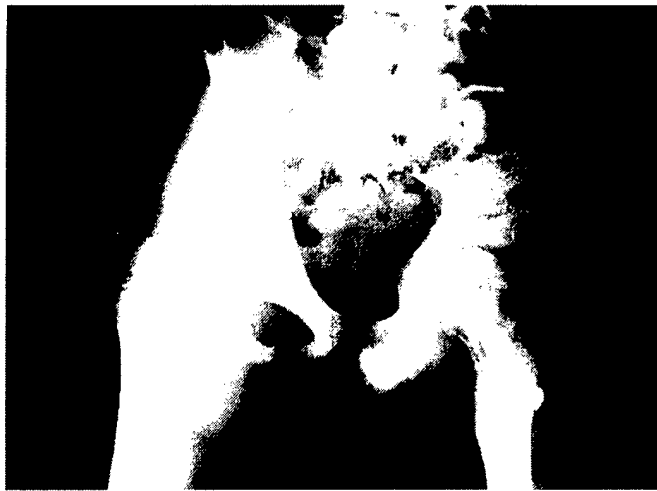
AP radiograph of the hip on arrival to the medical center. The pins are in good position, but destructive changes already can be seen.
